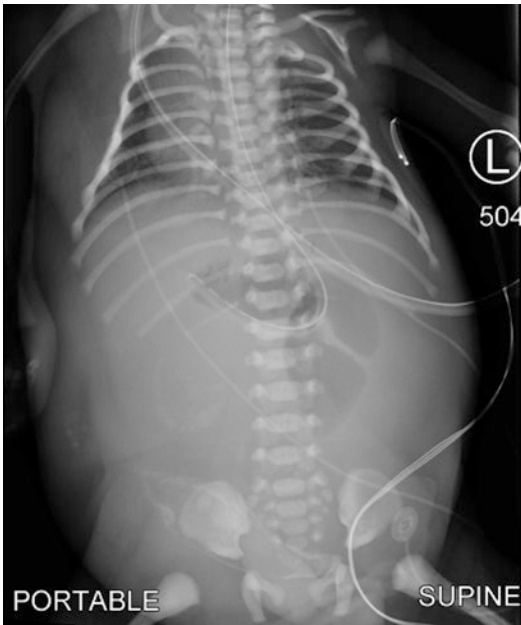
A chest and abdominal x-ray demonstrating bowel obstruction
